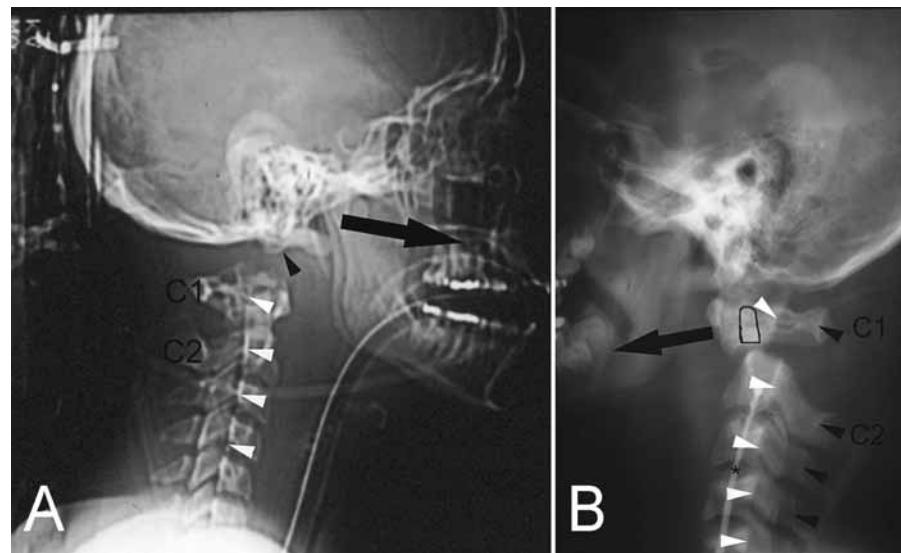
High cervical vertebral injuries. (A) Atlanto-occipital dislocation (lateral plain film). The white arrowheads indicate the ventral margin of the spinal canal, which should be aligned with the centre of the occipital condyle (black arrowhead). The large arrow indicates the forward direction of movement of the head on the atlas (C1), causing the spinal cord to be crimped between the dorsal margin of the foramen magnum above the site of dislocation and the ventral margin of the spinal canal below the dislocation site. Note also the widening of the gap between the atlas and the skull base. (Courtesy of Dr. D. Lee, London Health Sciences Centre, London, Ontario, Canada.) (B) Atlanto-axial dislocation (CT lateral "scout" film). The odontoid process (outlined) is displaced forward and lies at an angle because of a type 2 odontoid fracture. The atlas has moved forward, in the direction indicated by the large arrow, causing the spinal cord to be crimped between the arch of the atlas above and the dorsal margin of the vertebral body of the axis below. The ventral margins of the spinal canal are indicated by the white arrowheads and the dorsal margins by the black arrowheads. Note the marked step deformity between cervical vertebrae 1 and 2 in the line of the ventral margin of the spinal canal. An endovascular catheter is indicated by an asterisk. (Odontoid fractures occur in the body [type 1] or base of the odontoid process [type 2] or in the body of the axis at the base of the odontoid process [type 3]) (Courtesy of Dr. D. Lee, London Health Sciences Centre, London, Ontario, Canada.)
